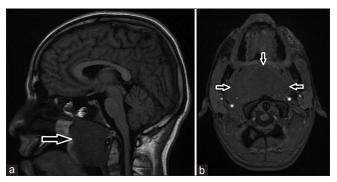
(a) Sagittal T1-weighted magnetic resonance image demonstrating a large homogeneous mass lesion (arrow) involving the nasopharynx and extending into the oropharynx in a biopsy-proven case of non-Hodgkin lymphoma, (b) Axial three-dimensional-time-of-flight magnetic resonance-angiography image demonstrating a large nasopharyngeal mass (arrows) and its homogeneous appearance. Symmetrical lymphoid tissue normally exists in the nasopharynx, as Waldeyer's ring, in which a primary lymphoma develops as demonstrated in the image
